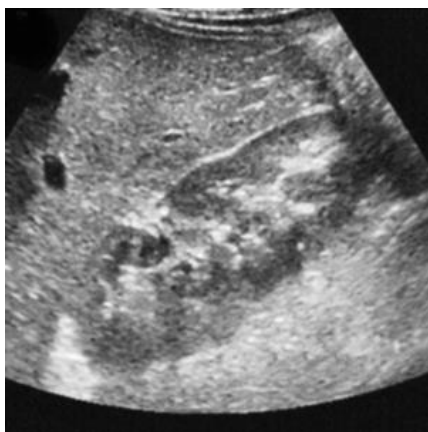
Ultrasound scanogram of the right kidney*
